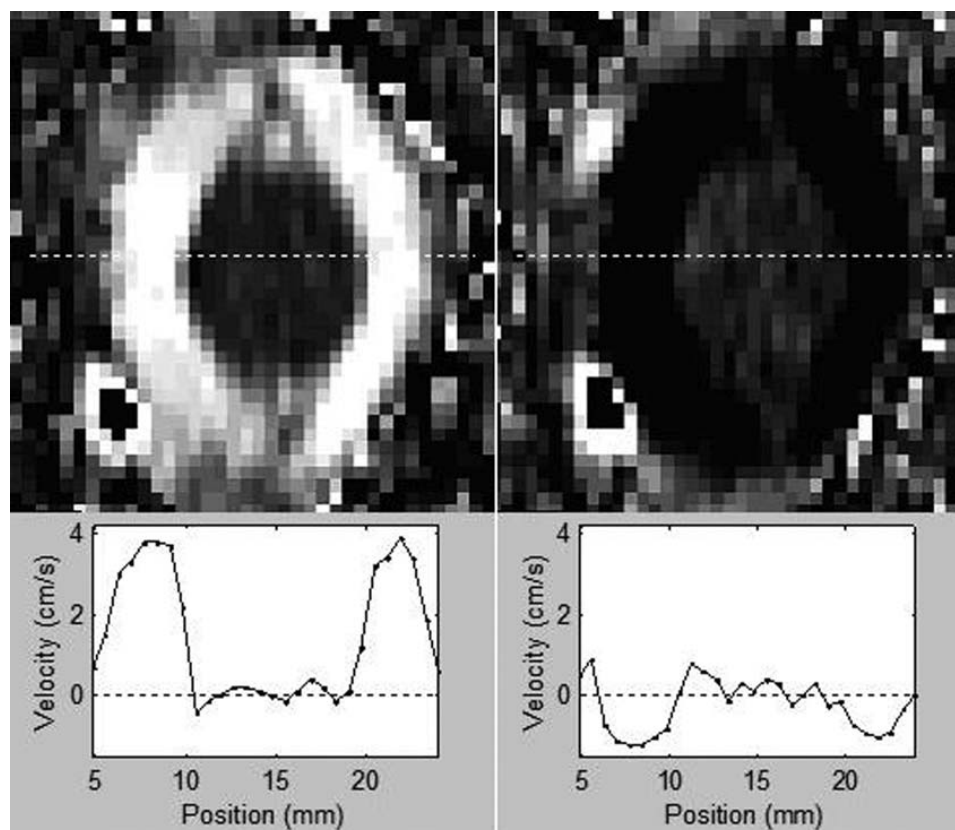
Phase-contrast magnetic resonance images of the pulsatile cerebrospinal fluid velocity observed during systole (left) and diastole (right) and with the corresponding velocity distribution at the location indicated by the white dotted line from Loth *et al.*⁴⁶ This demonstrates the blunt velocity profile that would typically be observed in the healthy spinal canal.
